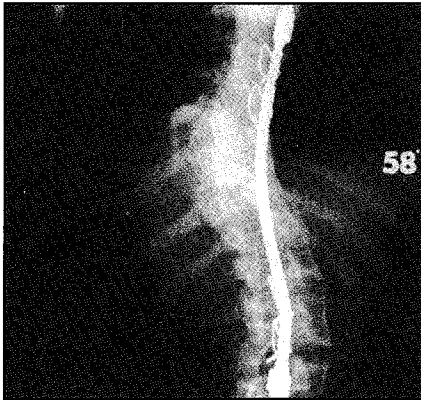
Post operative A-P radiograph showing the coronal curve corrected to 58 degrees.
